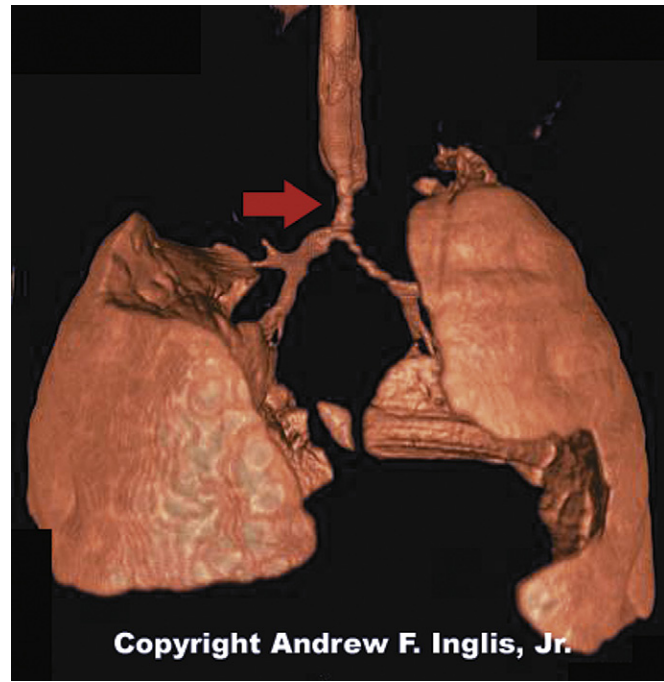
High-resolution three-dimensional reconstruction of CT scans clearly shows severe tracheal compression caused by vascular ring (arrow indicates tracheal narrowing caused by vascular ring). (Copyright Andrew F. Inglis Jr.)
